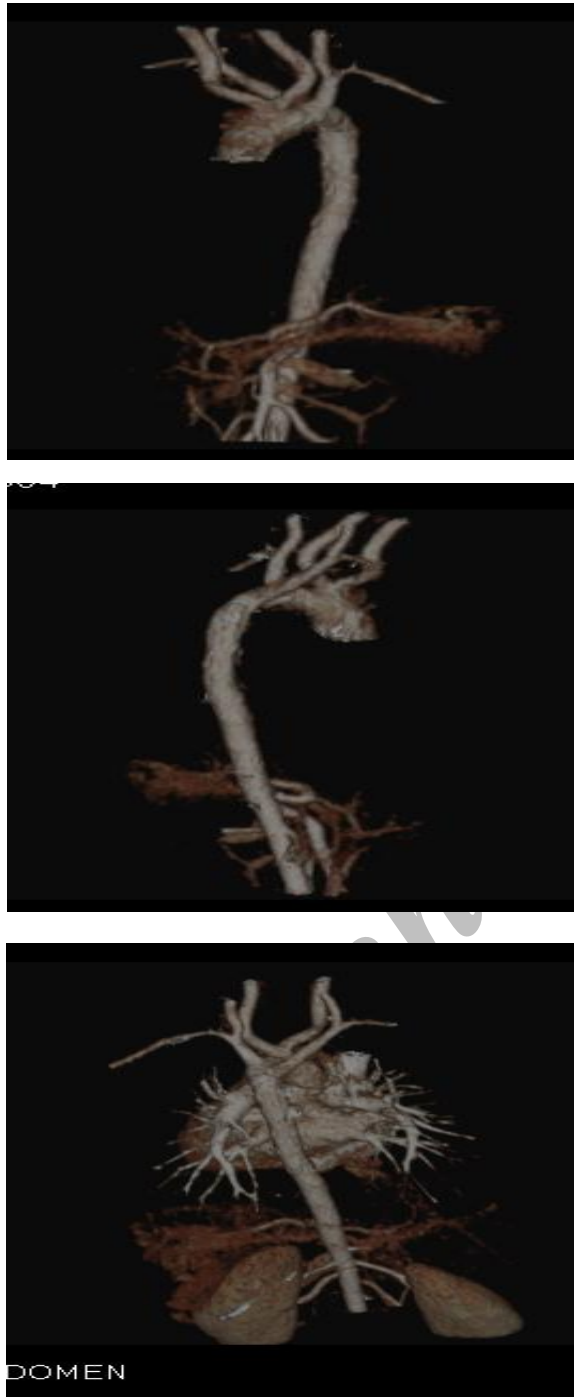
(a-c). CT Angiogram: The aberrant right subclavian artery arises from the aorta distal to the origin of the left subclavian artery and passes behind the esophagus.
